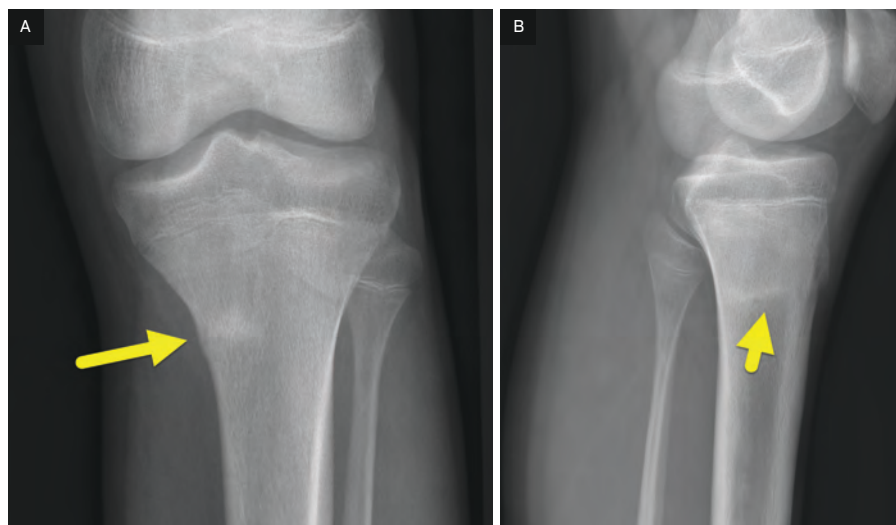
(A) Anteroposterior and (B) lateral radiographs performed 1 month later showing healing changes at the site of stress fracture with a linear band of sclerosis (arrow) and a healing periosteal reaction.
